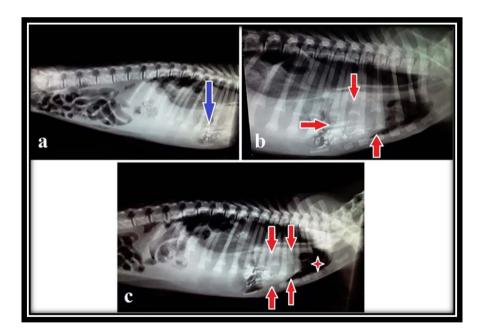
Direct radiography of the thorax and abdomen in the LL position: the diaphragm line cannot be seen (a,b,c), the view of the digestive system contents inside the thorax (blue arrow) (a), the silhouette view of the heart (red arrow) (b,c), free air in the thorax (star) (c).
